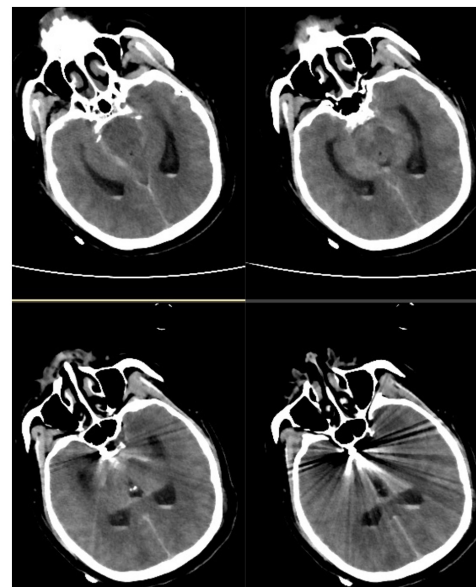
Cranial computed tomography on the first day after surgery. No new hemorrhage was detected in the re-examined head CT area.
